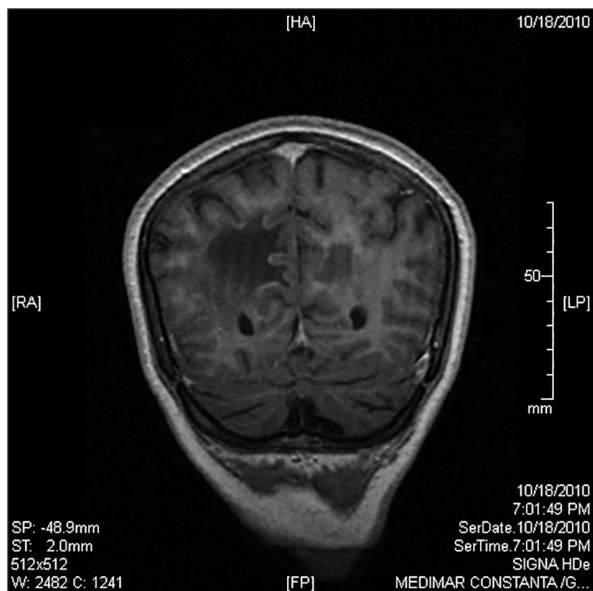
Cerebral MRI scan – the lesions appear hypointense on T1 weighted images, coronal view with peripheral contrast enhancement, without mass effect
